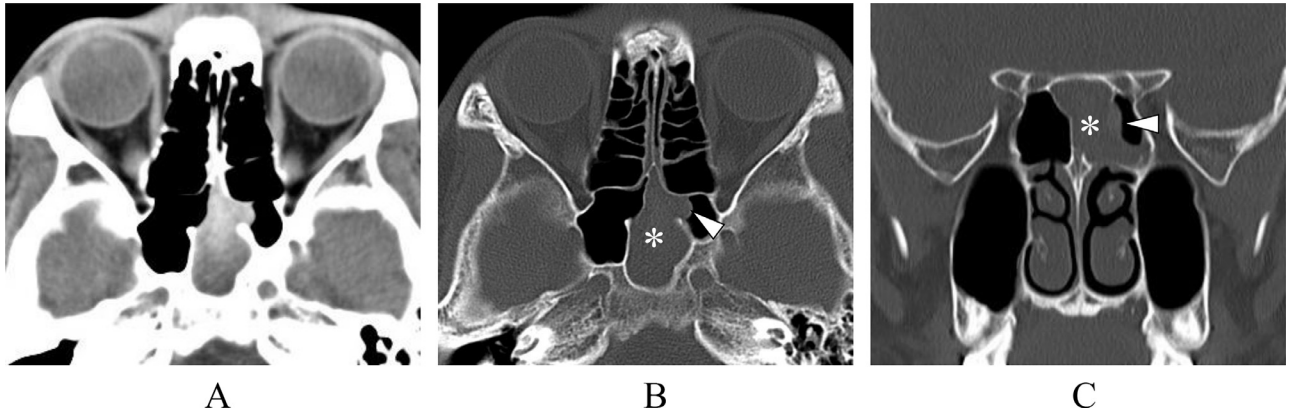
Preoperative plain CT findings. (A) Soft-tissue condition (axial image), (B) Bone condition (axial image), (C) Bone condition (coronal image). An internal heterogeneous solitary lesion was observed in the left sphenoid sinus (A), and an expansive mass (*) with bone thinning (arrowhead) was observed laterally anterior to the lesion in the left sphenoid sinus (B and C).
